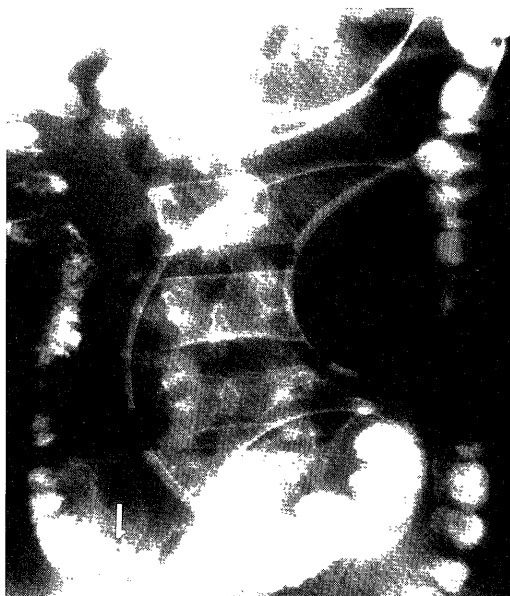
X-ray examination of the small intestine with gastrografin showing the so called "beak-like" filling defect in the terminal ileum.
